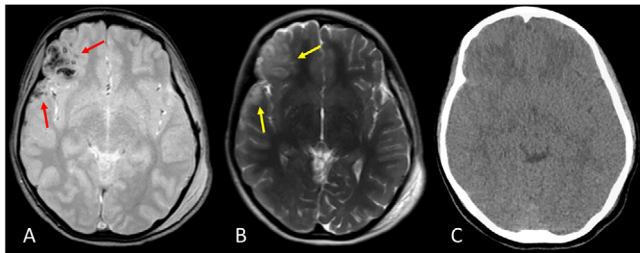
Cerebral hemorrhagic contusion on qbMRI. T_2^* image (A) depicts numerous foci of susceptibility in the inferolateral portion of the right frontal lobe and adjacent right temporal lobe (arrows), representing small foci of intraparenchymal hemorrhage. T_2 image (B) depicts hyperintense signal abnormality representing cerebral edema associated with the hemorrhagic contusions. Non-contrast axial CT image (A) through the same level of the brain appears normal.
